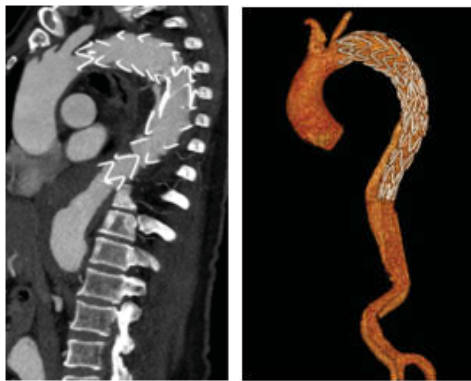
Type B aortic dissection CT aortogram stretched aorta view.
